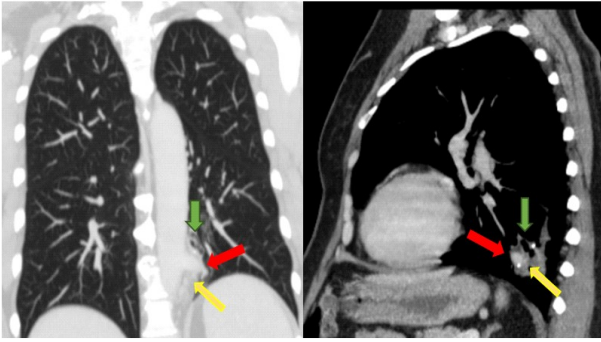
Computed tomography in the axial plane in lung window. The image shows subpleural nodular formations with soft tissue density (yellow arrows), a branching opacity in the central portion of the involved segments, which represents dilated mucus-filled bronchi - mucocele (green arrow) associated with hypertransparency of the lung parenchyma, which is supplied by the atretic segment due to hypovascularization (red arrows).
